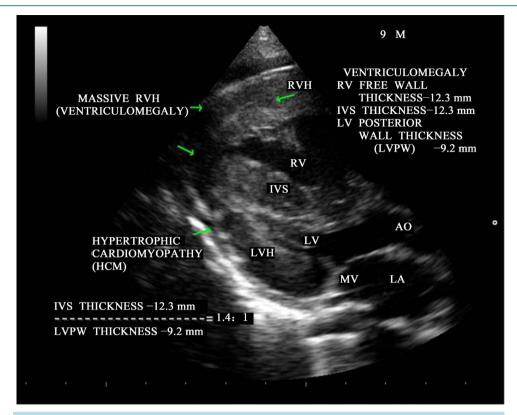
Parasternal long axis view showing HCM (hypertrophic cardiomyopathy).
